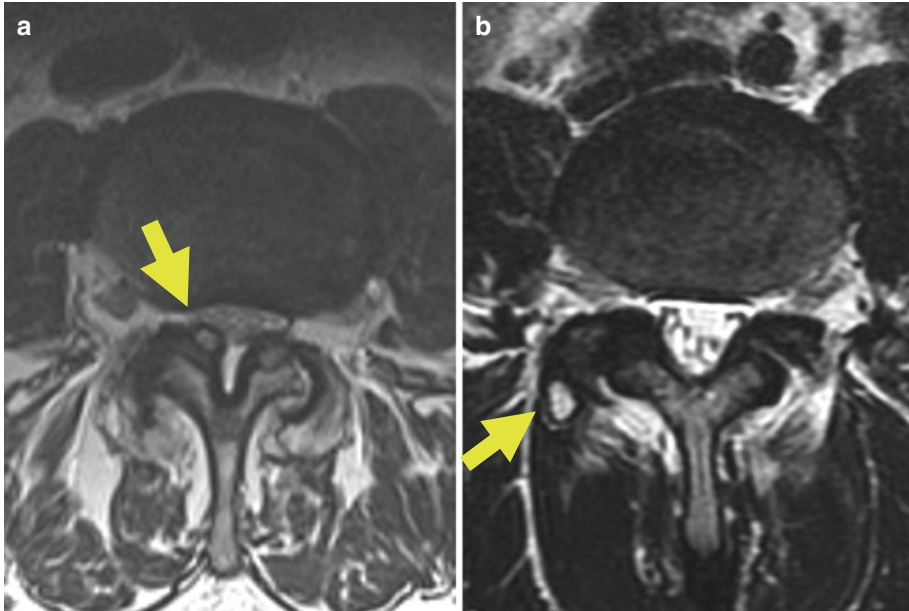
Axial T2-weighted imaging of the lumbar spine demonstrates an intracanalicular synovial cyst (arrow) in (a) and an extracanalicular synovial cyst (arrow) in (b)
